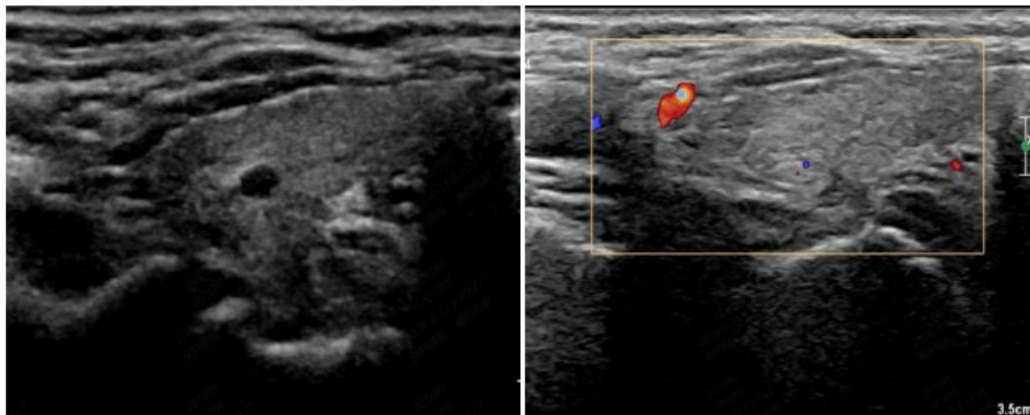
Thyroid color Doppler ultrasound image.
